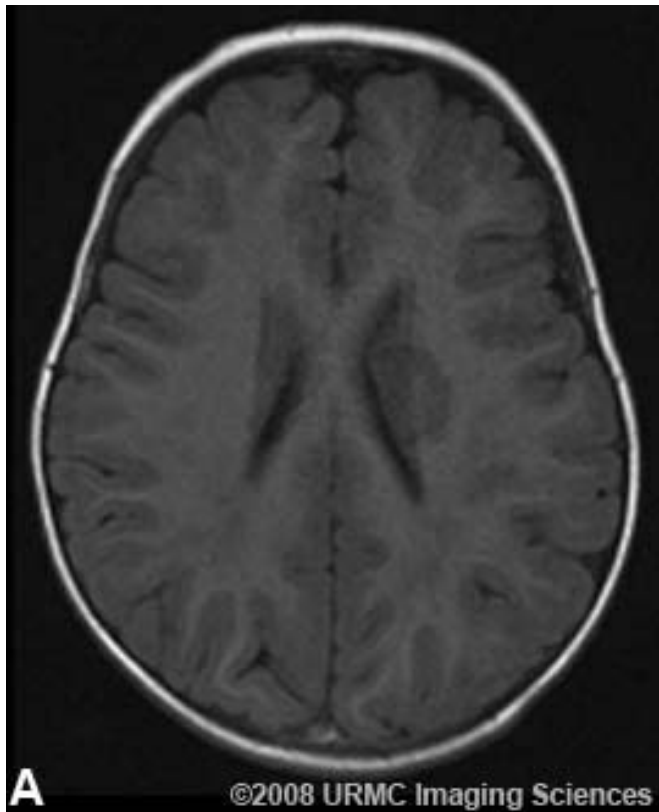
Axial images through the area of interest reveal well-demarcated low signal on T1-weighted (A) and high signal on T2-weighted FLAIR (B) sequences characteristic of an hyperacute infarct.
